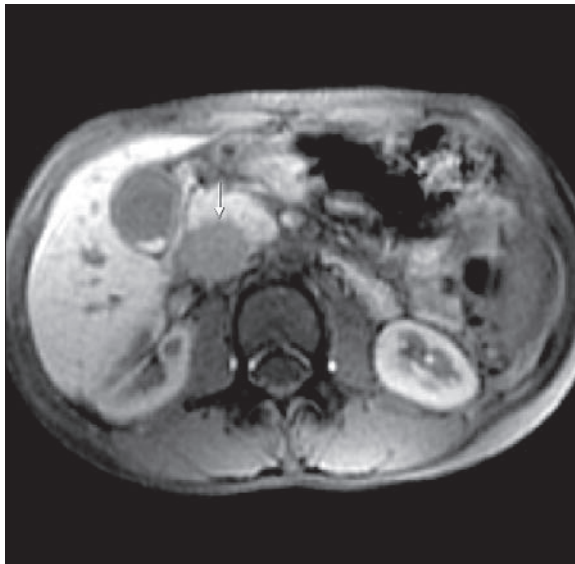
Abdominal MR. Axial T1-weighted fat-suppressed image. Round, hypointense, 3 cm tumor in the head of the pancreas (arrow).
